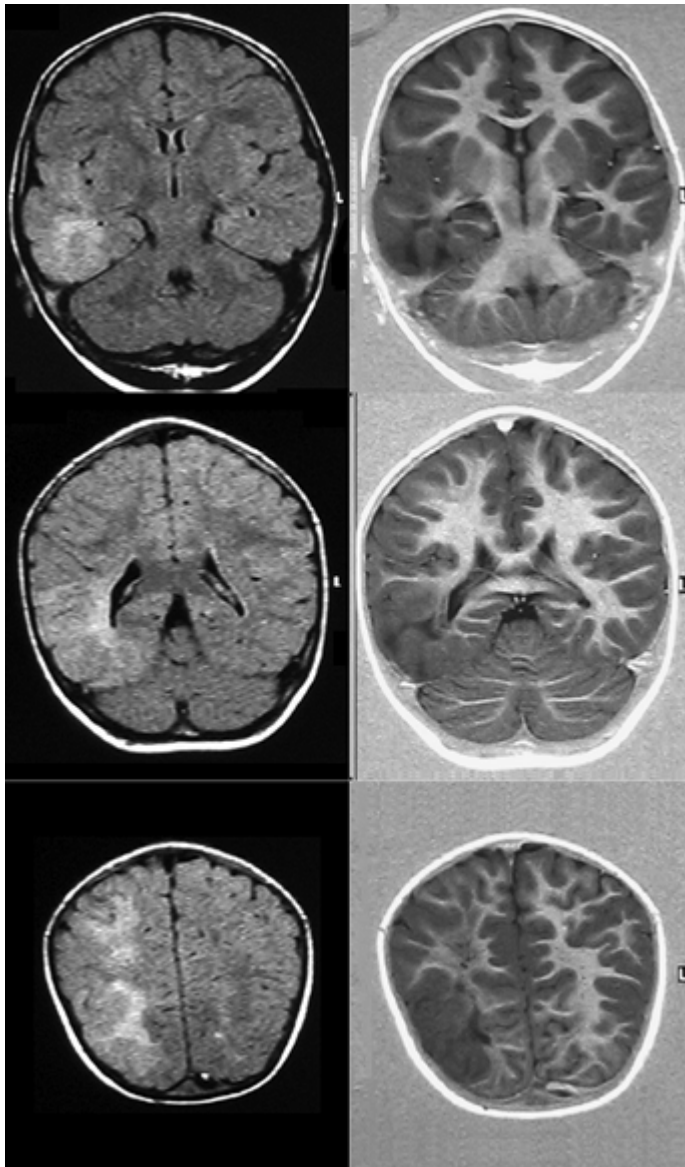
Multilobar resection for hemispheric cortical dysplasia in a 4-year-old male who presented with intractable seizures. Fluid-attenuated inversion recovery (left) and spoiled gradient-echo (right) magnetic resonance images demonstrate a right temporal-parietal-occipital lesion consistent with hemispheric cortical dysplasia at three different coronal levels. An extended right temporal-parietal-occipital lesionectomy was done with electrocorticography. Pathology demonstrated focal cortical dysplasia type IIb.
